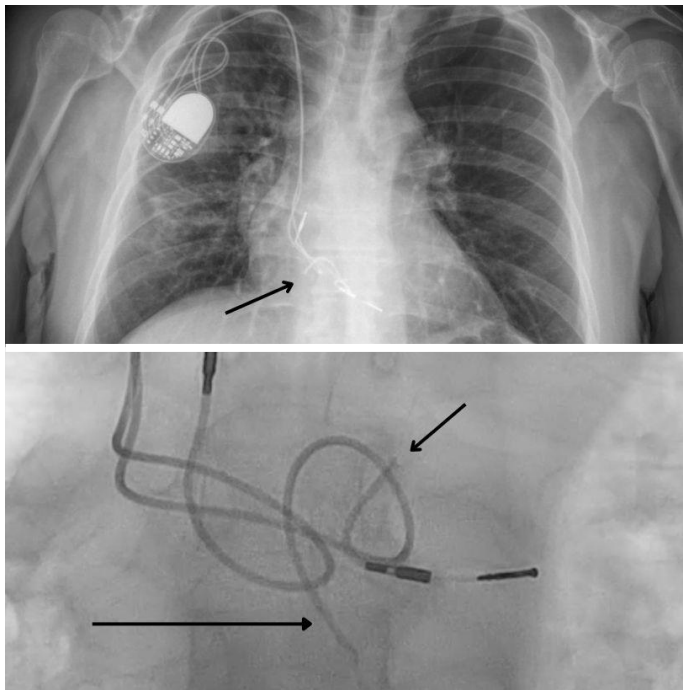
Images of the patient's lead fracture as seen in posteroanterior (PA) and anteroposterior (AP) radiographs and fluoroscopic examination.
